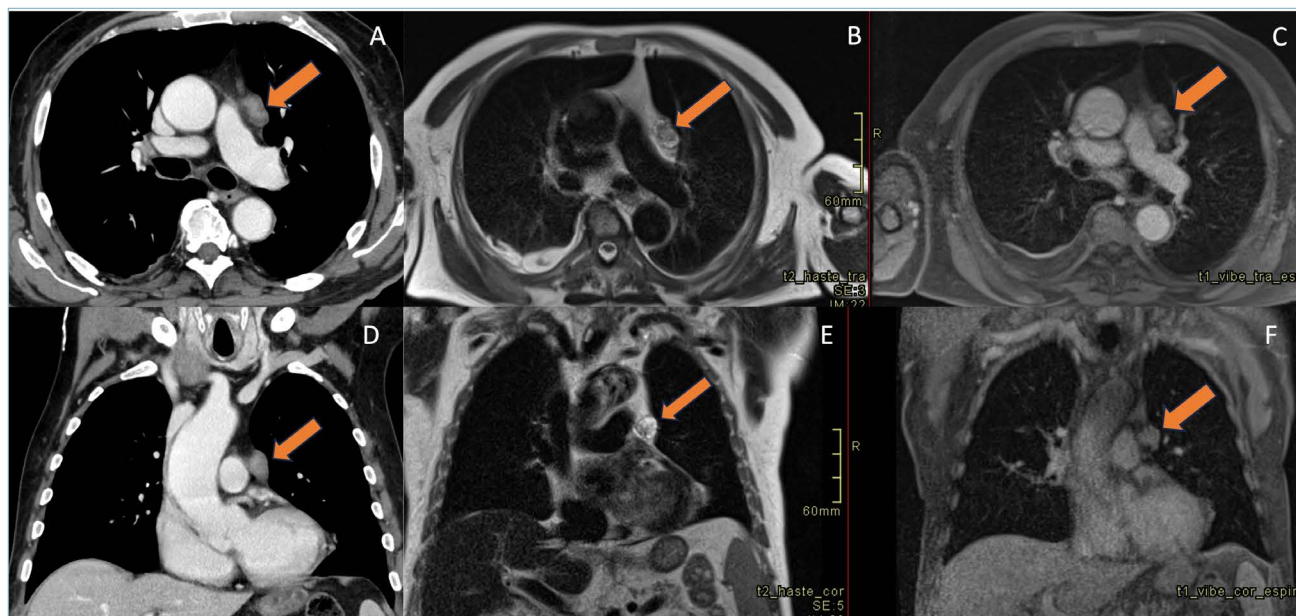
A) Axial and D) coronal post-contrast CT imaging revealed a poor enhancement of a small, rounded well-defined lesion; B) Axial and E) coronal non-contrast-enhanced T2-weighted MRI scans showed hypointensity, within a heterogeneous anterior mediastinal lesion extending into thymic rest. C) Axial and F) coronal post-contrast-enhanced T1-weighted MRI scans showed a homogeneously enhanced lesion.
